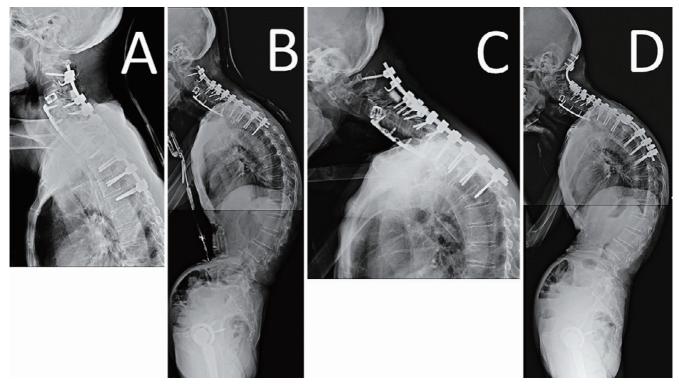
(A) Images after third operation (posterior fusion with C2 to Th5). X-ray just after posterior fusion. (B) Standing lateral X-ray at 1 month shows anterior shifting of loading axis of the head and deterioration of dropped head. (C) X-ray at 2 months shows multiple reconstruction failure (anterior cervical plate was dislodged, C2 pedicle screws were pulled out, and Th5 vertebra developed compression fracture). (D) Images after fourth operation (extension of posterior fusion with C0 to Th8). Standing lateral X-ray shows that the loading axis of the head still exists far anterior of the sternum (CGH-C7 SVA, 101 mm).
